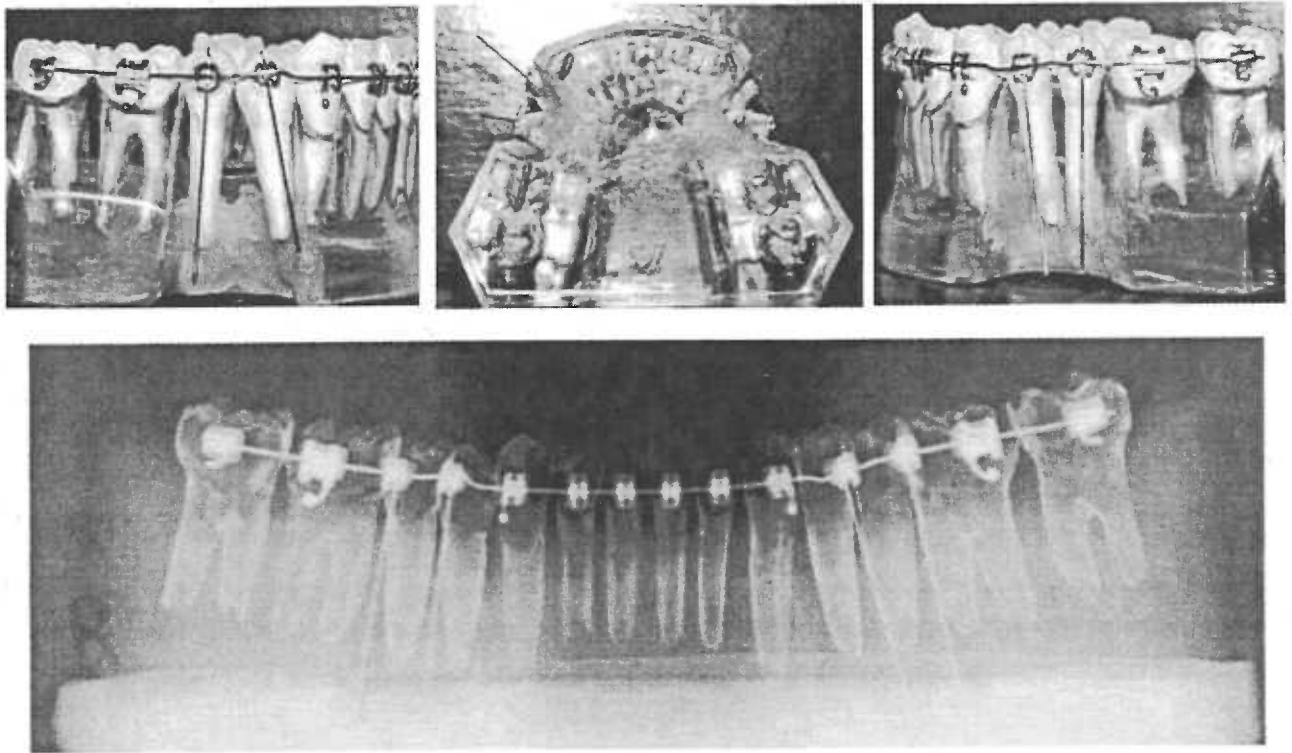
Example of distortion displayed on panoramic radiographs. Digital photographs of mandibular first premolars with unparallel roots and the corresponding panoramic radiograph showing parallel roots.
